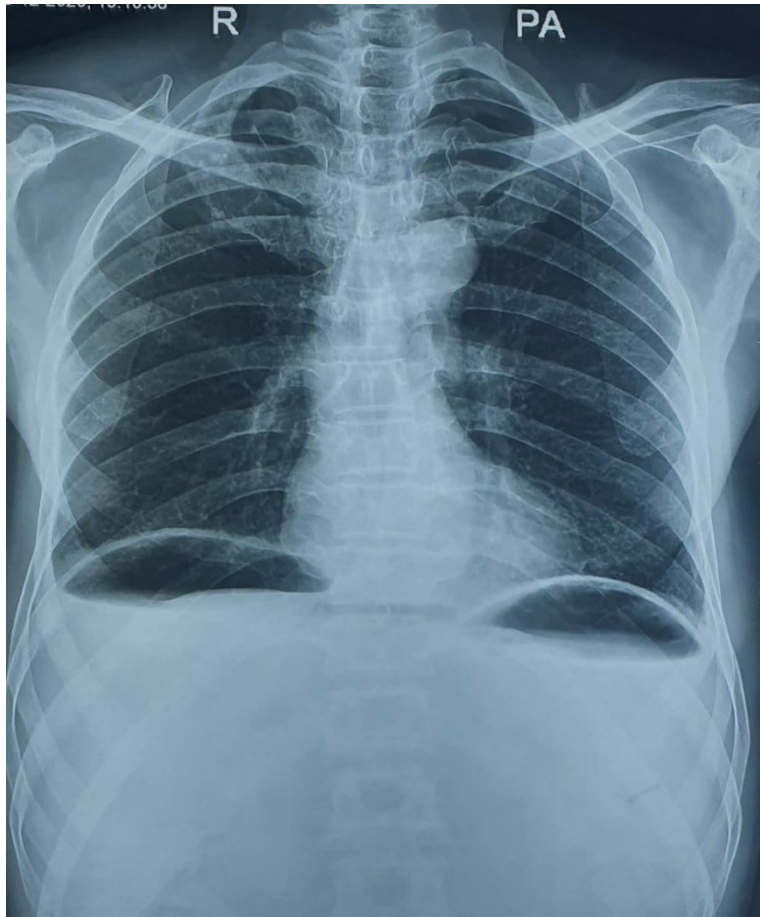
Plain radiograph showing free gas under diaphragm
